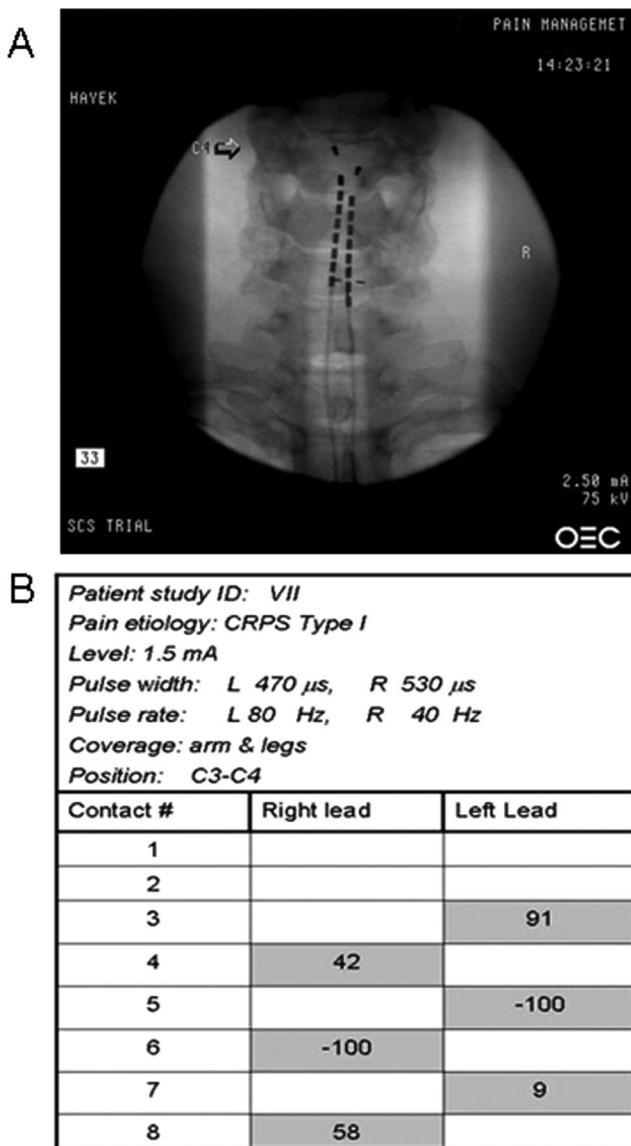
Cervical placement of dual spinal cord stimulator leads for four-extremity paresthesiae coverage. (A and B) Cervical spinal cord stimulation in a patient with complex regional pain syndrome type I. (A) Radiograph displaying cervical spine with spinal cord stimulator lead tips at C4. (B) Stimulation parameters that achieved four-limb paresthesiae for the patient described. Note that both leads are used, and the current is fractionated through three nonconsecutive contacts (right contacts 4, 6, and 8 and left contacts 3, 5, and 7).
